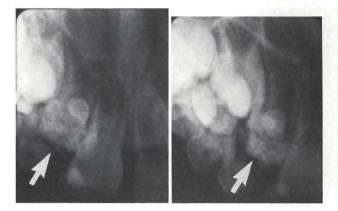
L and R. Periapical radiographs show radiopaque mass in the area of the central incisor.
